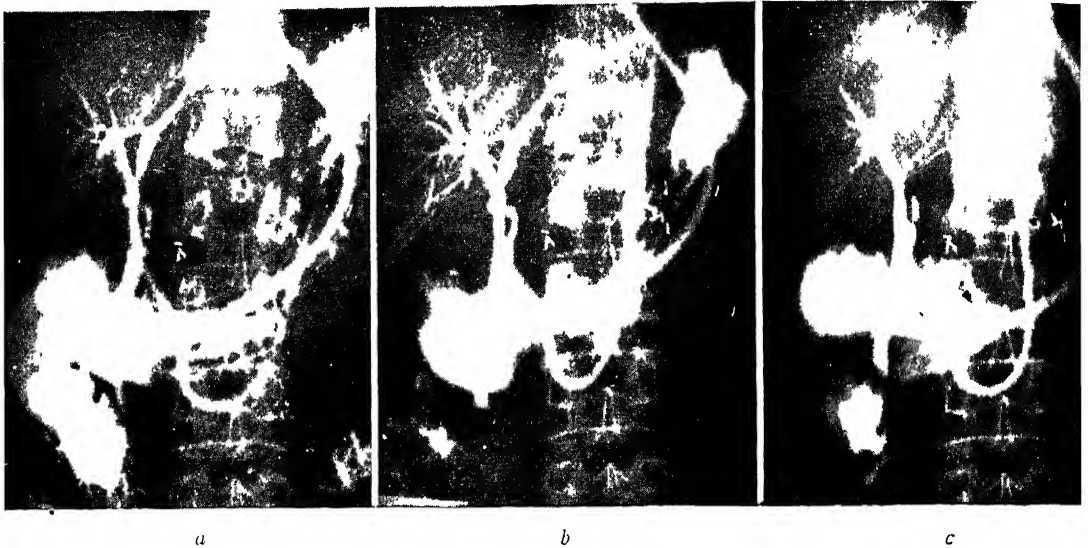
Serial roentgenograms after simultaneous injection of the common bile duct with brominol through a T-tube and of the duodenum with barium: *a*, at rest; *b*, 10 minutes after administration of morphine sulfate, showing spasm of duodenum and reflux of medium into the finer radicles of the biliary tree; and *c*, after inhalation of amyl nitrite, showing relaxation of duodenal spasm and decrease in amount of medium in the bile ducts. (Surg., Gynec. & Obst., 66: 979-987, June, 1938.)
